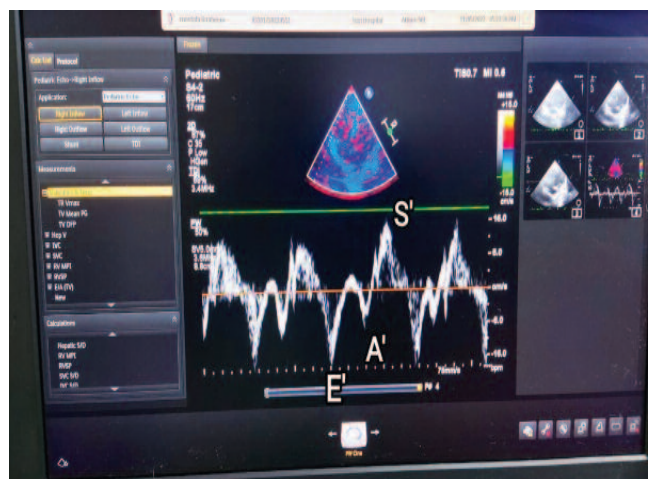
Tissue Doppler of right ventricle (RV), with the cursor positioned in the lateral border of tricuspid annulus measuring two major negative velocities E' and A'. Major positive systolic velocity was recorded at S'.
